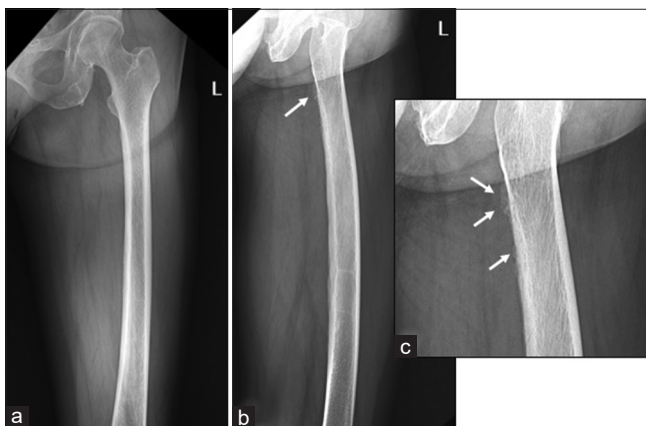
A 55-year-old female with upper thigh pain. (a) AP and lateral (b) radiograph of the left femur shows a focal cortical thickening and irregularity on the posteromedial aspect (white arrows), (zoomed on “c” showing additional areas).
